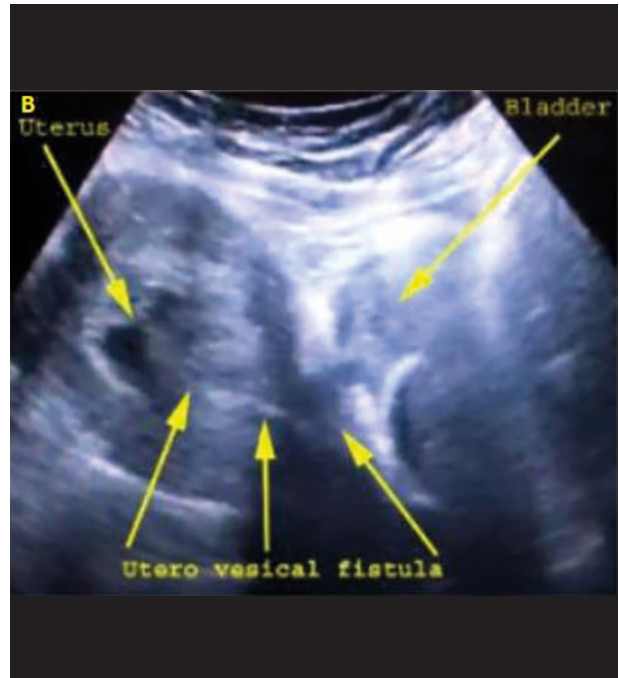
B: Ultrasonographic view of the uterovesical fistula tract.
